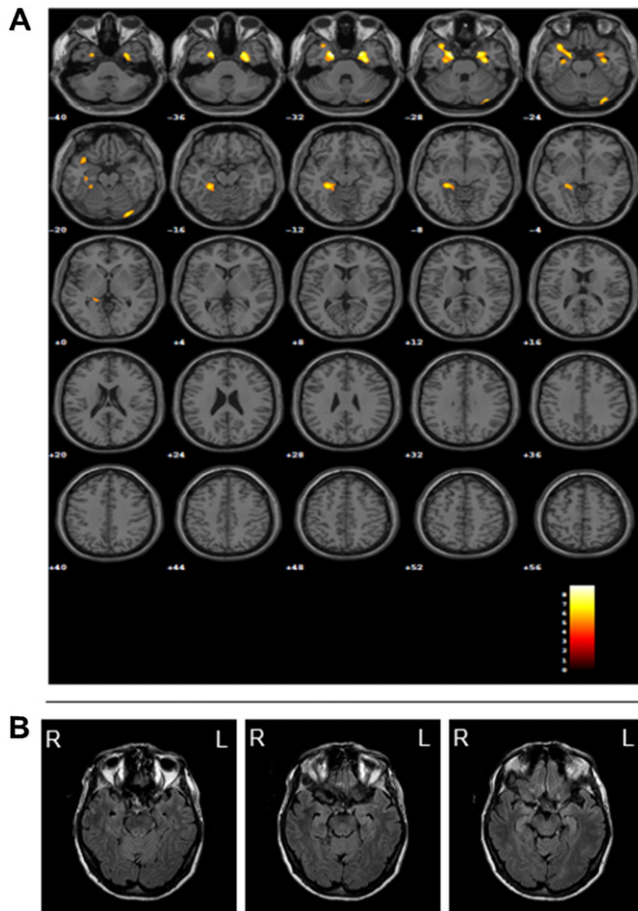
The SPM-t map of hypometabolism of an amnesic single domain MCI with mTLD-pattern displayed on axial view of an MRI standardized structural scan showing a selective temporo-mesial hypometabolic pattern (A). Axial T1-weighted MRI images showing mild-moderate selective temporo-mesial atrophy more pronounced on the left side (B). L = left; R = right.
